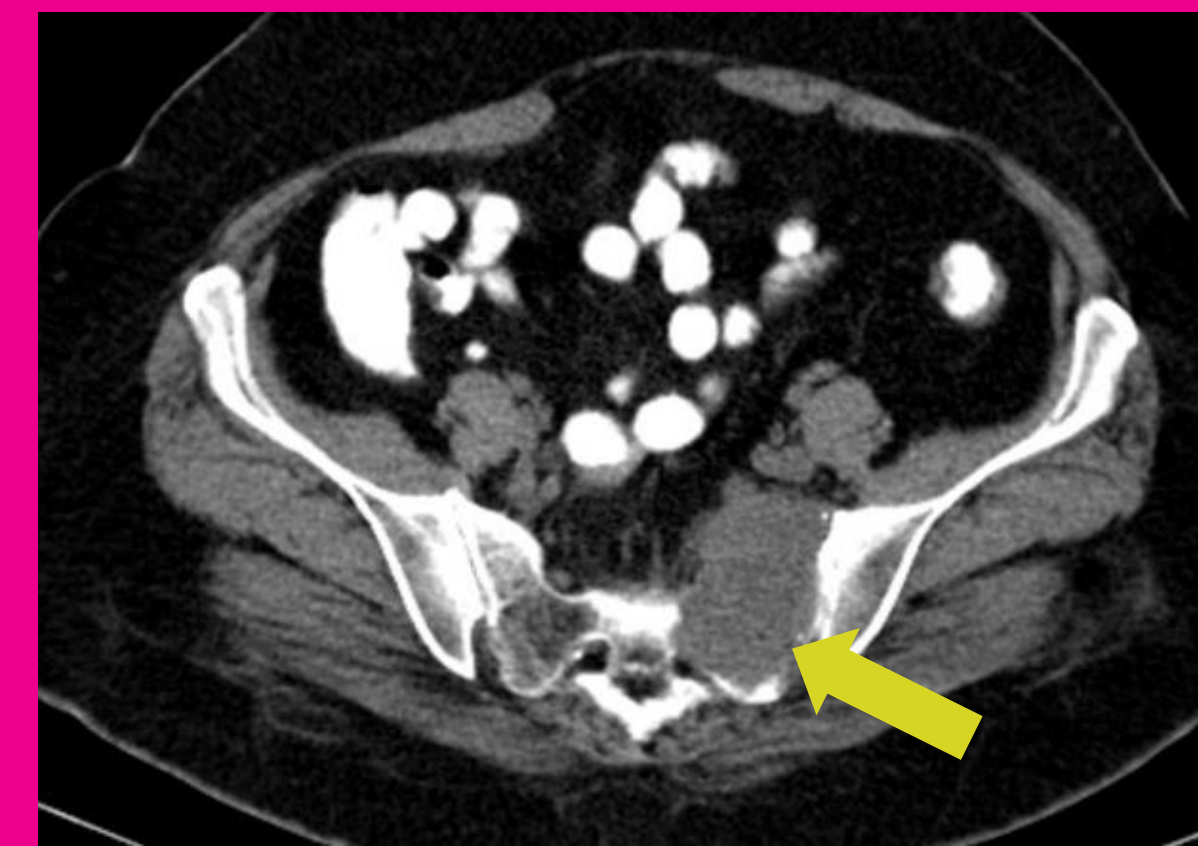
Axial CT of the pelvis of a BC patient demonstrates a bone metastasis with soft tissue component of >10 mm (arrow) and is considered measurable by RECIST 1.1.
